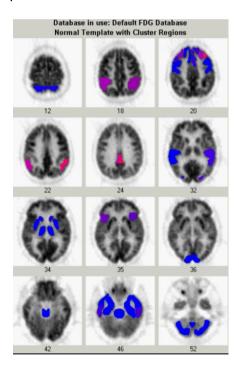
Hypometabolism in bilateral parietal lobes associated with severe cognitive dysfunction on lamotrigine. PET Scan: The patient was imaged on a GE Discovery whole body PET/CT scanner approximately 60 minutes after the intravenous administration of F18-fluorodeoxyglucose. A standard brain protocol was performed. At visual assessment, there is decreased uptake in the bilateral parietal lobes with sparing of the sensory-motor cortex, at least 3 standard deviations below database values. There are also more subtle areas of hypometabolic activity in the bilateral frontal regions. Standard deviations below normal: Blue 2-3, Purple 3-4, Pink 4-5, Red 5-6.
